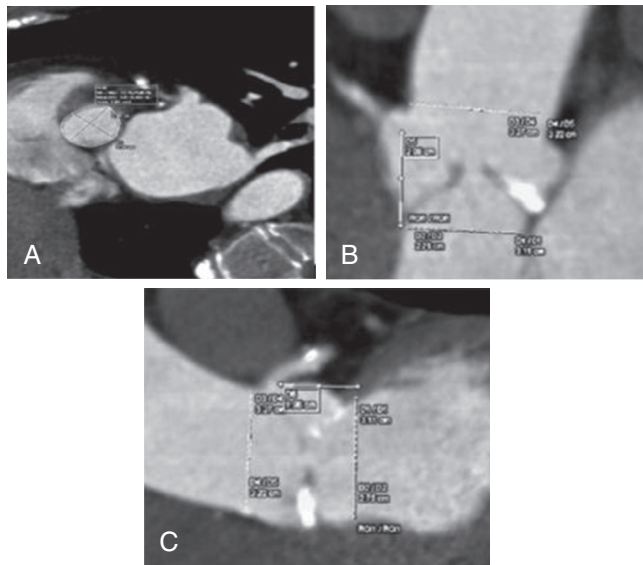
■ Cardiac contrast computed tomography with three-dimensional reconstruction measuring the aortic annulus area. A-C, Multiple views on computed tomography of the aortic annulus that are required for evaluation of the aortic valve for preoperative TAVR planning.
